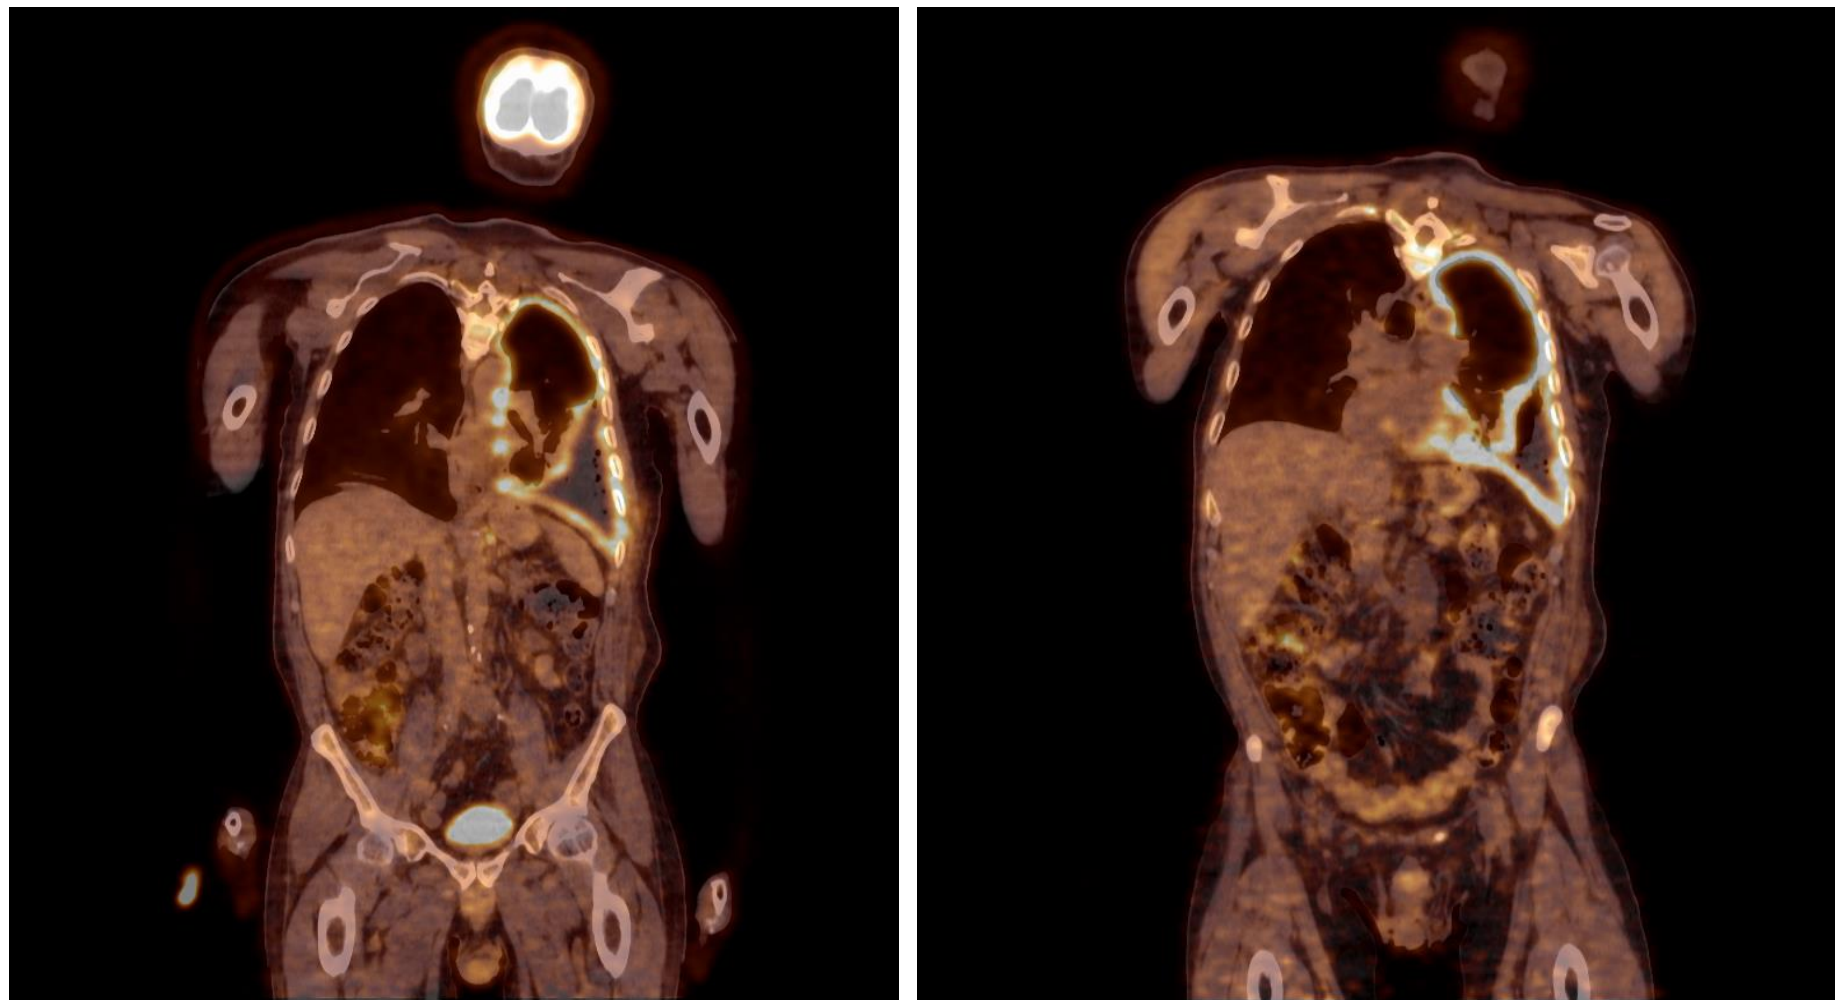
Total body PET/CT 59 y, M 1.73m, 81kg (left 9:53 scan time- right 11:36 repeat scan time), prescribed dose 7.7mCi, injection time 8:47.
